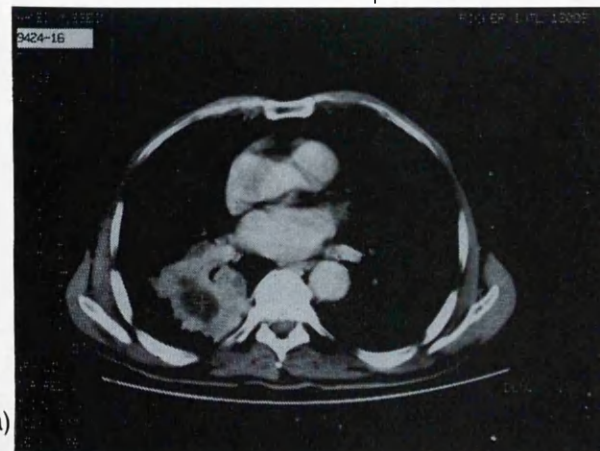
CT scans before therapy (a) and after therapy (b) do not show significant changes.
